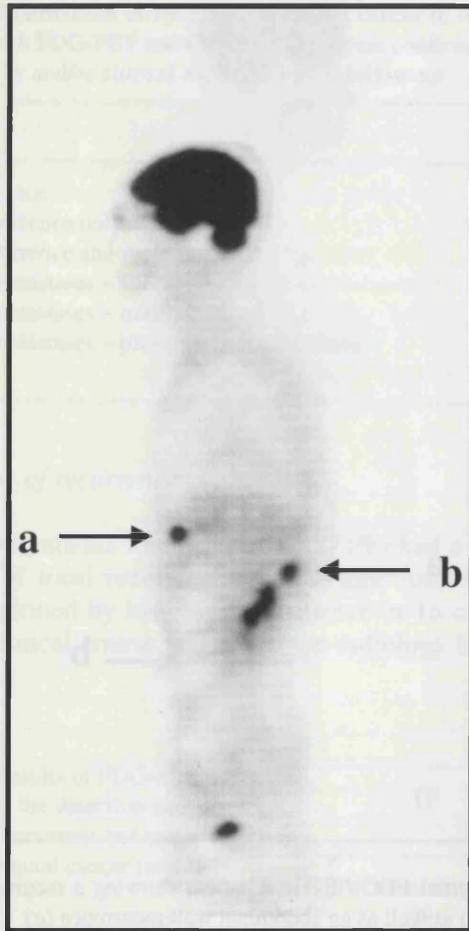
Sagittal FDG-PET in a patient showing a recurrent pelvic tumour (b) as well as an abdominal wall recurrence (a)
